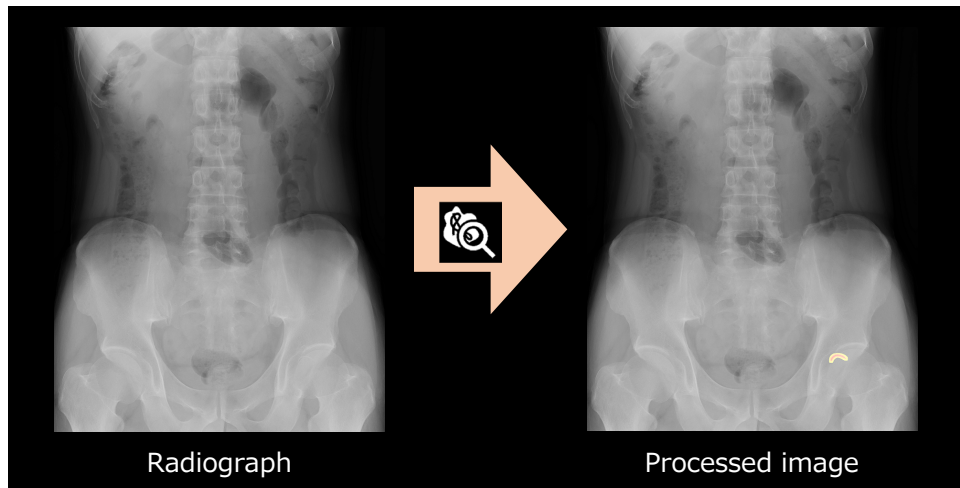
Abdominal Radiograph and Image Processed by Smart DSI
